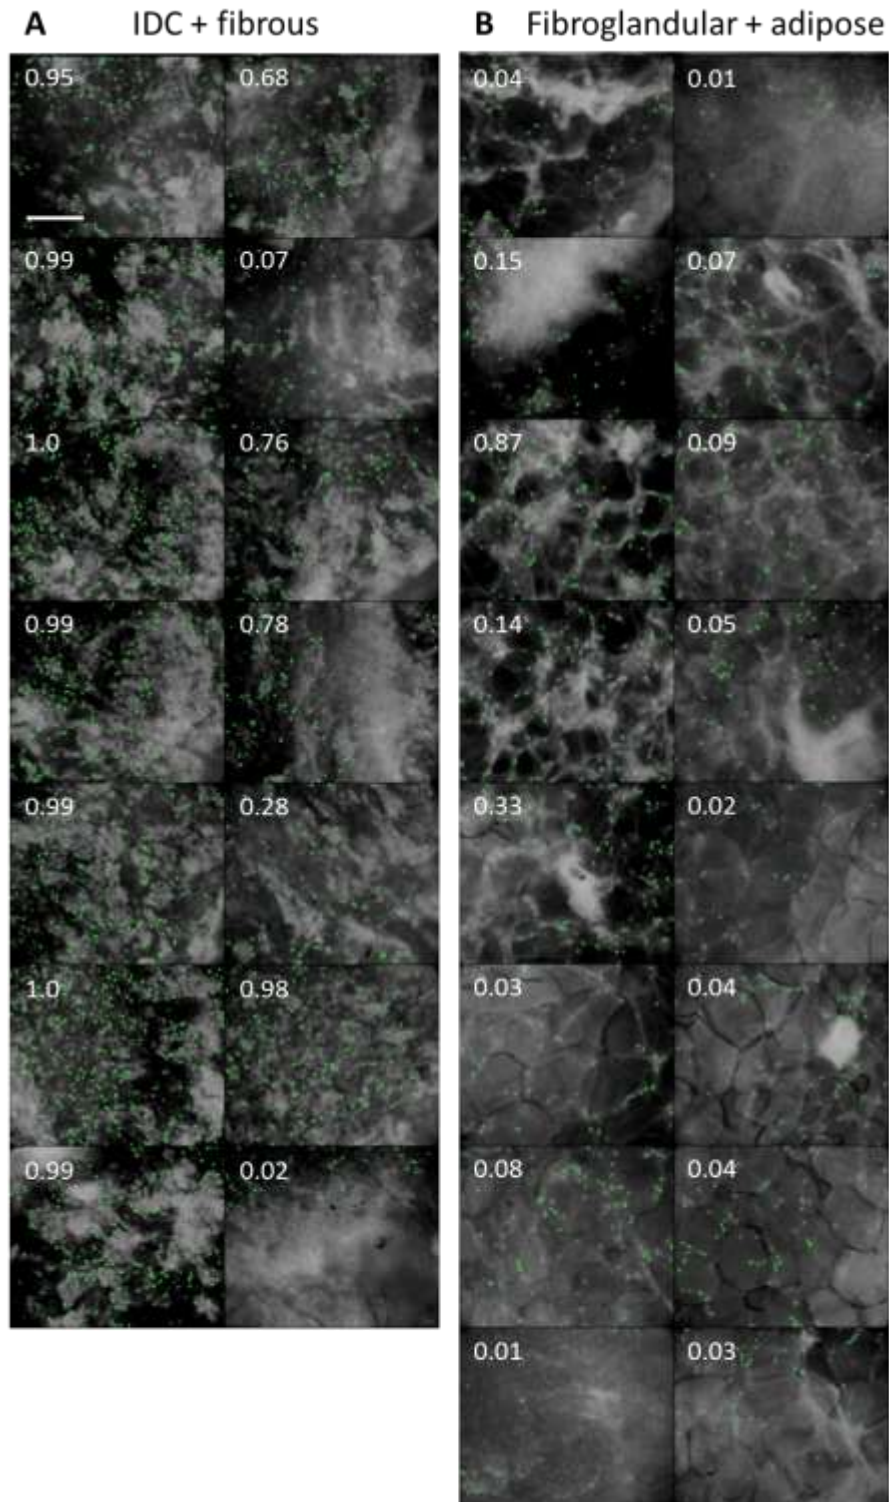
The application of an algorithm based on SCA+CT applied to representative biopsy panels. A representative positive and negative breast biopsy panel are shown in A and B respectively. Each side of the biopsy was scanned length-wise—side 1 corresponds to the left column and side 2 corresponds to the right column. Images are shown as an overlay in which the smaller acriflavine positive features (APFs) ($<7\ \mu\text{m}$ diameter) are false colored green. The
